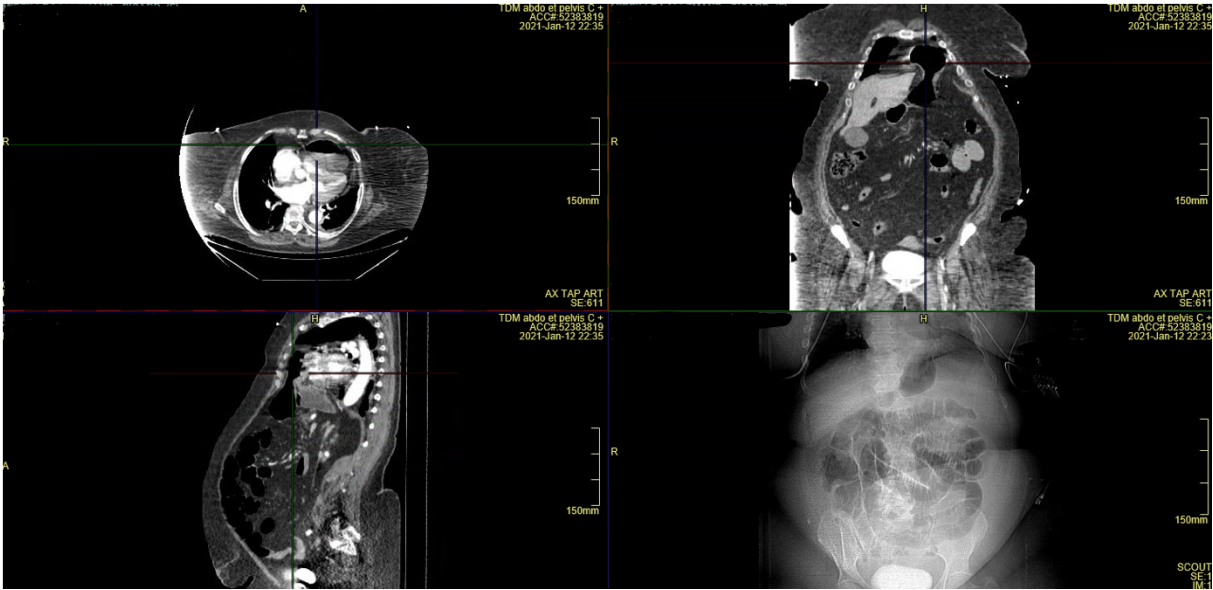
Whole-body CT scan at the entrance of the emergency department. The diaphragm is intact and there is no intra thoracic additional image.
